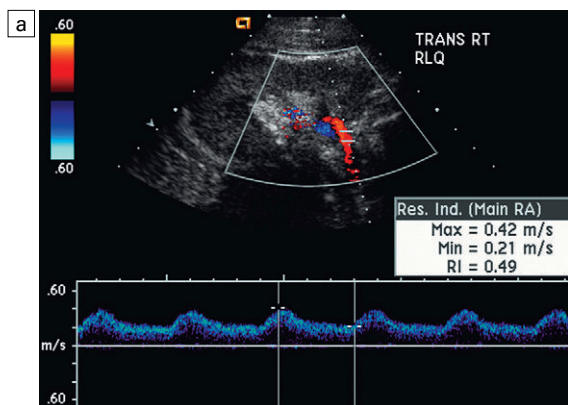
(a) Renal transplant arcuate artery spectral Doppler tracing in a hypertensive recipient with elevated serum creatinine. The renal arterial waveform manifests tardus parvus waveform with a slow systolic upstroke, and a rounded systolic peak, relatively low resistance. These findings suggest a more proximal stenosis. (b) Spectral Doppler tracing just beyond the anastomosis of the main renal artery to the iliac artery. Note the high velocity (1.79 m s^{-1}), turbulent flow characteristic of renal artery stenosis. (c) MR angiogram of this transplanted kidney actually revealed a double arterial anastomosis. The lower pole artery shows a high grade stenosis (arrow) within 1 cm of its anastomosis.
